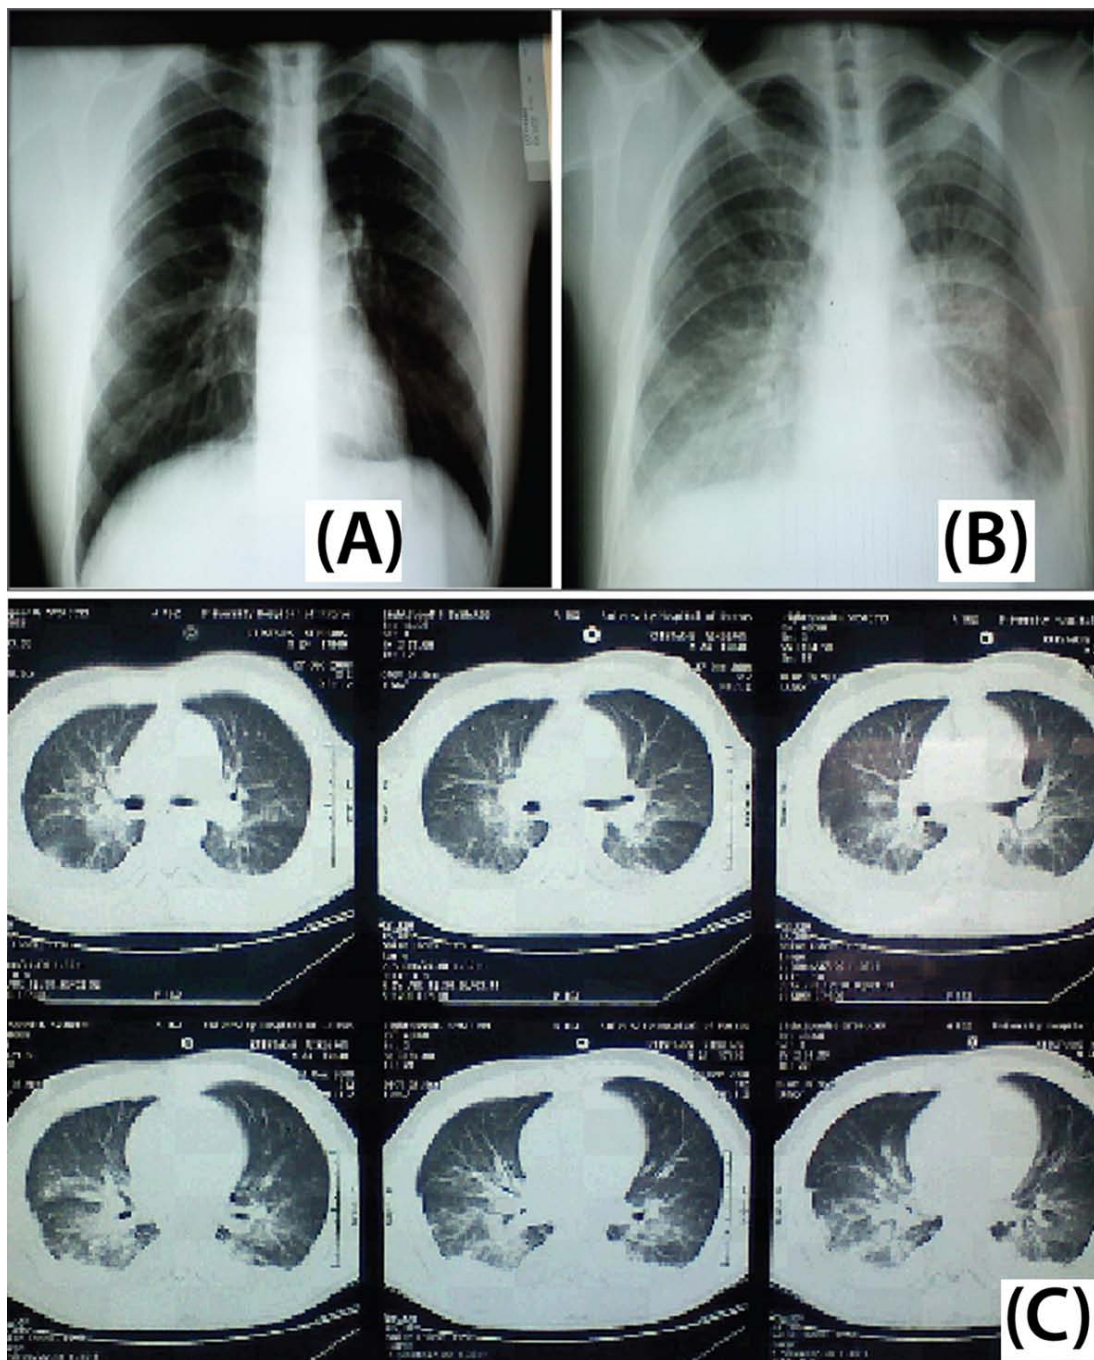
Patient imaging studies. (A) Chest X-ray on day 5. Reticulo-micronodular infiltrates at the right lung base. (B) Chest X-ray on day 12. Bilateral reticulonodular infiltrates expanding from basal bronchopulmonary segments towards the hila and upper lobes. (C) Chest CT scan on day 12. Extensive central bilateral infiltrates, including atelectatic lesions and pleural effusions are depicted bilaterally.
